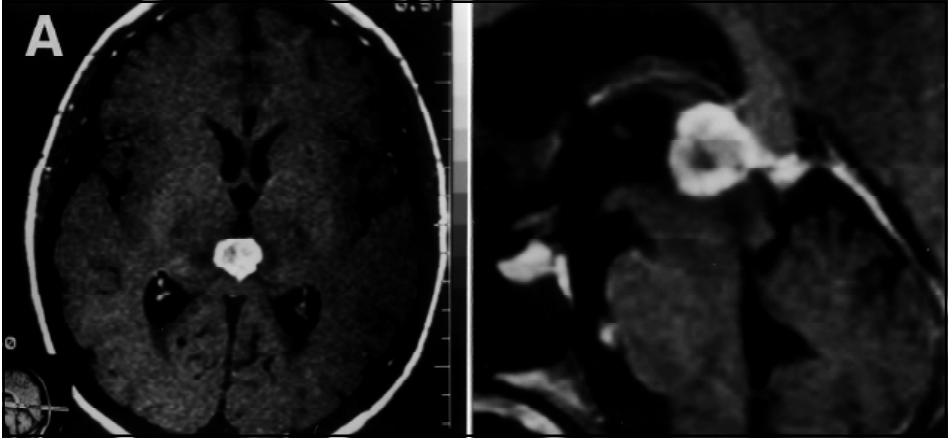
MRI T1-weighted axial (A) and sagittal views after gadolinium injection showing hyperintense lesion compressing mesencephalon and quadrigeminal plate.
